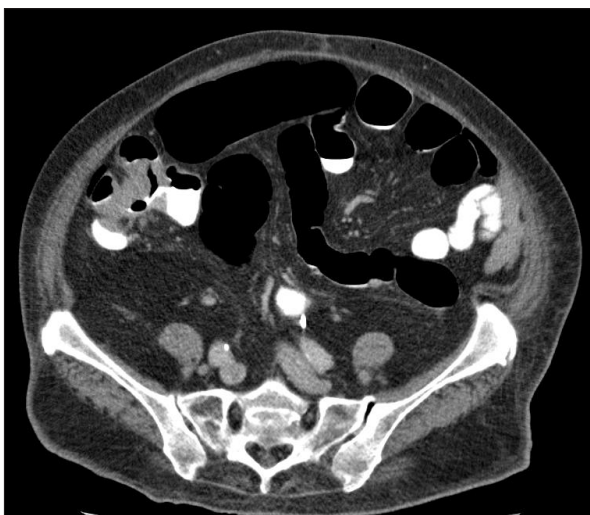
CT abdomen: caecal tumour.
